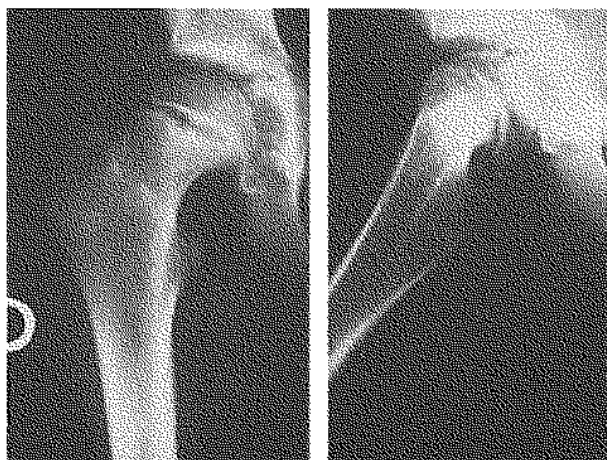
Preoperative radiographs of the right hip showing a grade-I slipped capital femoral epiphysis.
